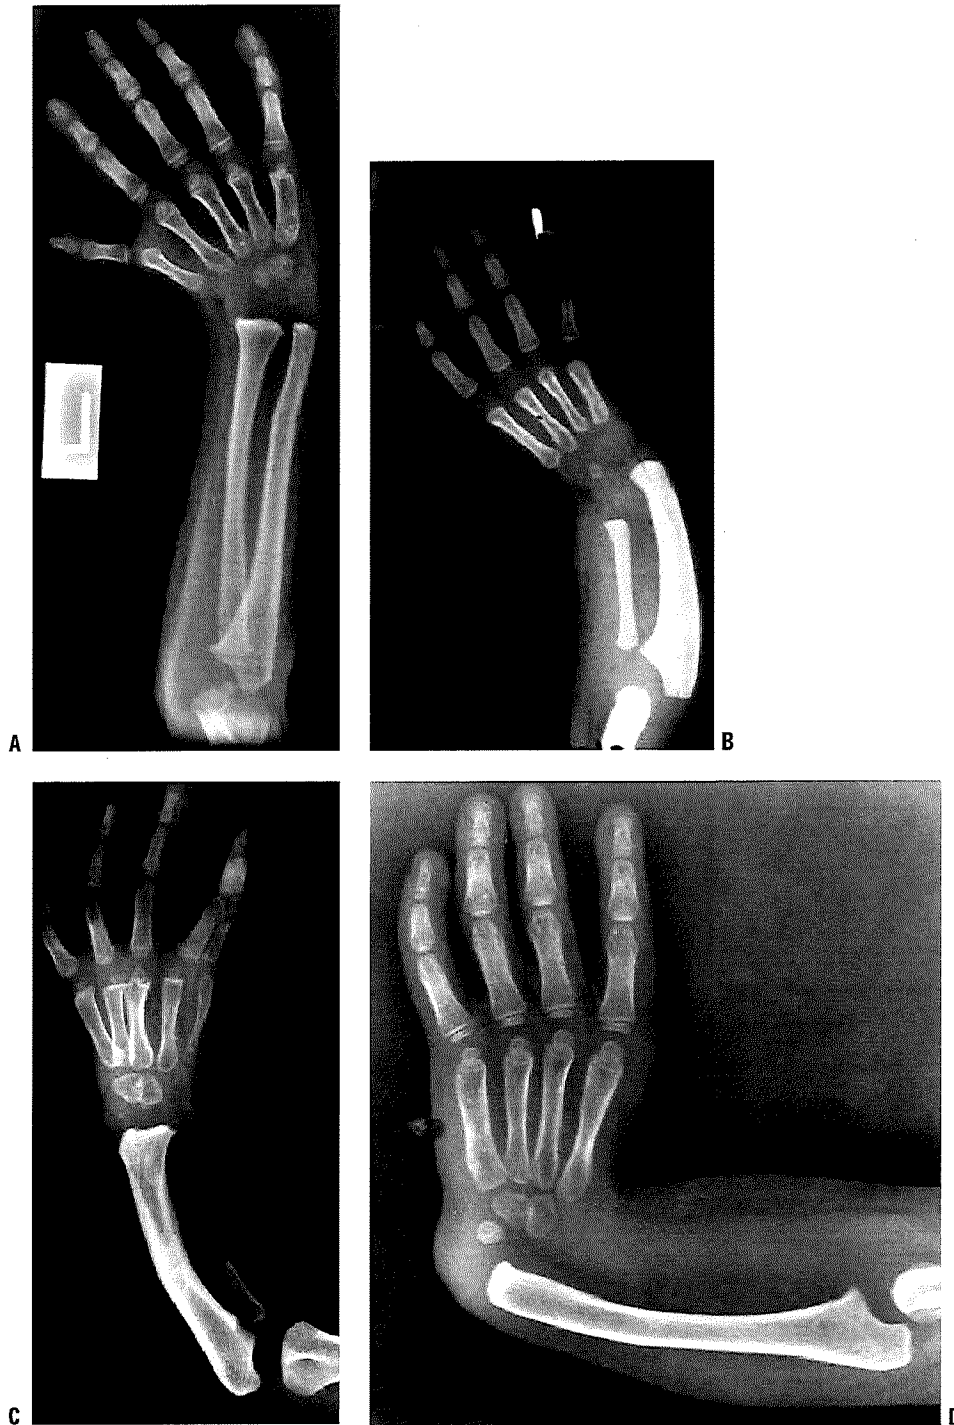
Classification of radial dysplasia types I through IV as represented by radiographs. A: In type I, the ulnar variance is positive as a result of the foreshortened distal radius. B: In type II, both the proximal and distal radial physes have deficient growth, with more radial shortening and ulnar bowing. C: In type III, the radius is partially absent. D: In type IV, the radius is completely absent.
